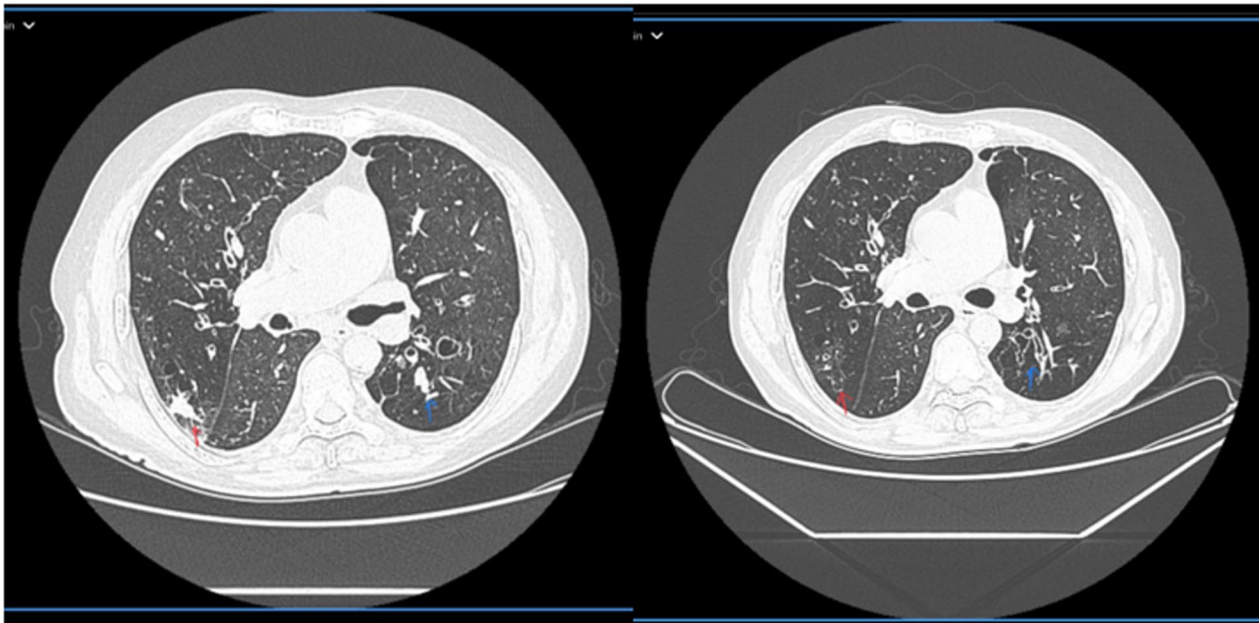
The red arrow in figure on left side shows a consolidation patch and blue arrow shows mucoid impaction. Figure on right side is a follow up CT and red arrow shows resolution of consolidation & blue arrow shows resolution of mucoid impaction
